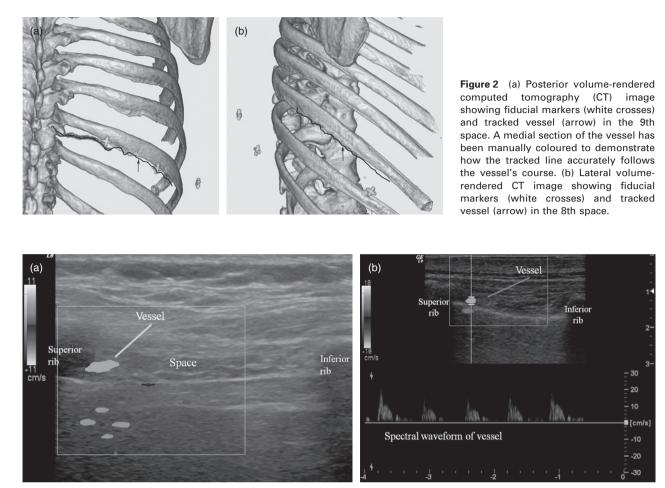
(a) Doppler image of the vessel using the 8 MHz linear ultrasound probe. (b)-Pulse wave Doppler image of the vessel. Note: there is a mirror image of the vessel deep to the pleural line.
